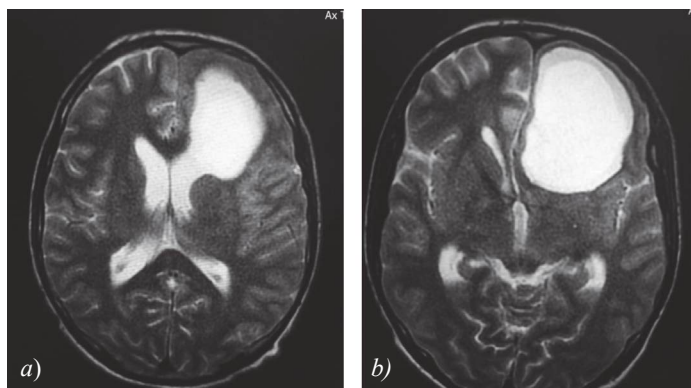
Brain MRI. A cystic lesion in the left frontal lobe pressing against the adjacent brain tissues and adjacent structures (a, b)
